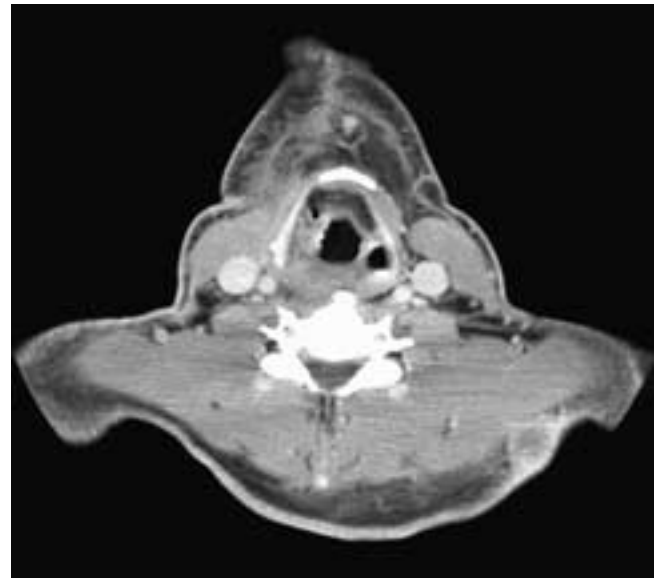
Axial contrast-enhanced CT scan shows a mass in the skin and subcutaneous tissues of the left posterior neck. The margins of the lesion are unsharp. This was a rare skin metastasis from a pharyngeal squamous cell carcinoma. Note the postoperative changes in the right anterior neck from the primary tumor resection.
